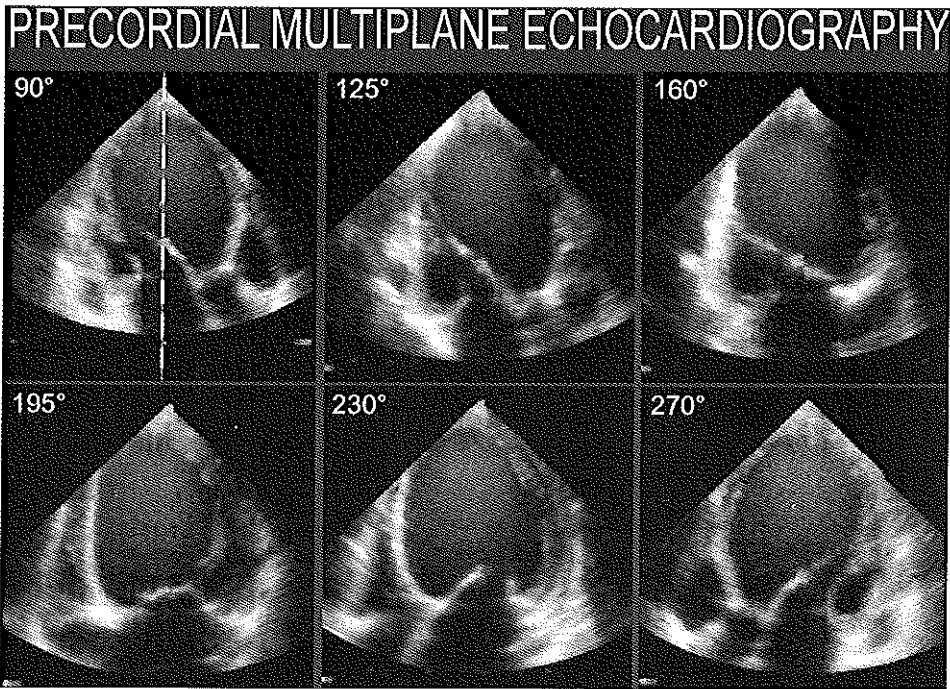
Apical (precordial) multiplane echocardiography of a patient with a dilated left ventricle. Under computer control, the imaging plane is rotated over 180° starting with a left ventricular long-axis plane and with steps of 35°. The axis of rotation is indicated in panel A. All images are recorded in the same phase of the respiratory cycle. Images A and F are mirror images. The images can be recorded on videotape or optical disc for further analysis. Increments of 2° during acquisition allow the completion of a rotational dataset for three-dimensional reconstruction.
